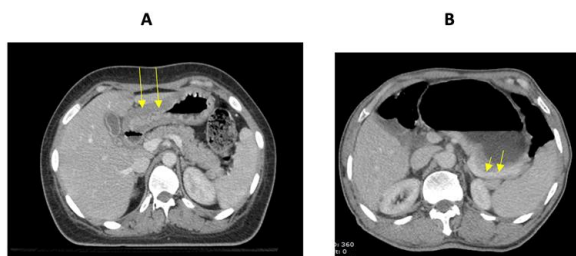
CT scans of two patients with SRCC
